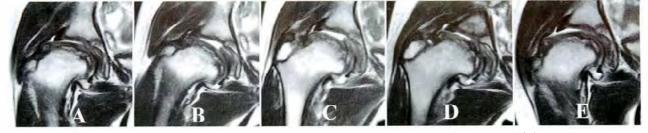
SROM MRI taken at different positions of the hip: (A)neutral, (B) abduction, (C) abductioninternal rotation, (D) abduction internal rotation flexion, and (E) adduction.
